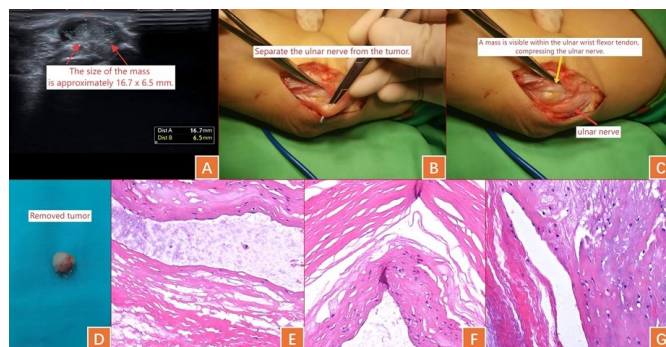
(A) Elbow joint ultrasound examination revealed a mass measuring approximately 16.7 × 6.5 mm within the ulnar wrist flexor tendon sheath. (B) A pale-yellow tumour was observed within the ulnar wrist flexor tendon sheath. (C) The tumour capsule was incised, and the tumour was clearly visible. (D) The tumour was completely removed and sent for pathological examination. (E-G) Pathological examination revealed an ulnar wrist flexor tendon sheath cyst, with a gray-white and gray-brown cut surface, which was solid in nature, firm in texture, and showed focal mucous deposits.
